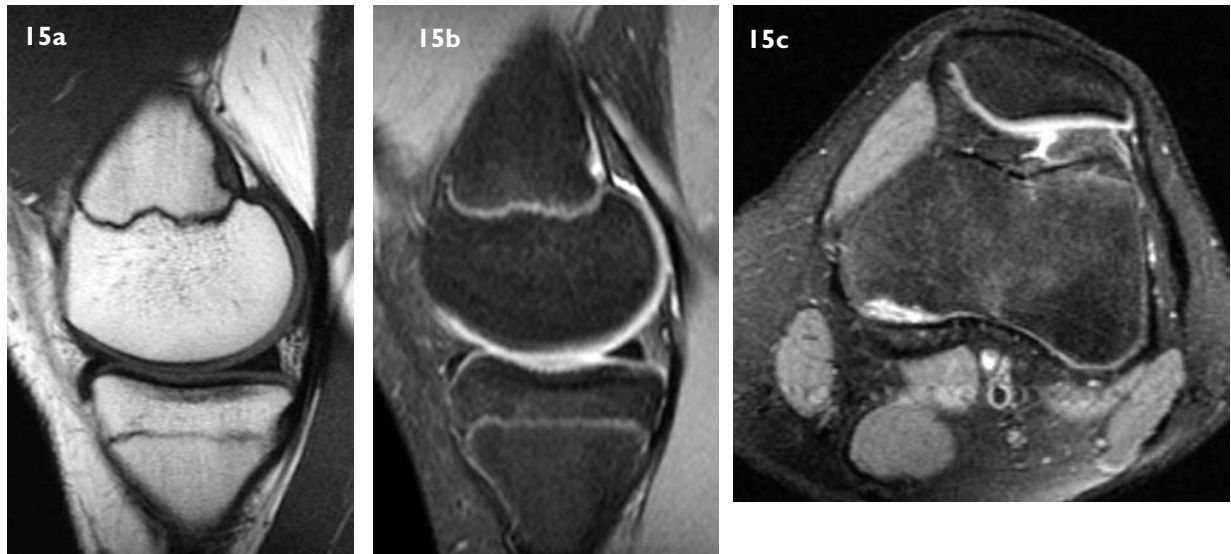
Cortical irregularity of the left distal femur in a 16-year-old boy. (a) Sagittal SE T1-W MR image shows the irregularity as a well-defined hypointense lesion. The lesion has a high signal intensity on the (b) sagittal fat-suppressed T2-W and (c) axial TSET2-W MR images. There is no periosteal reaction or associated soft tissue mass.
